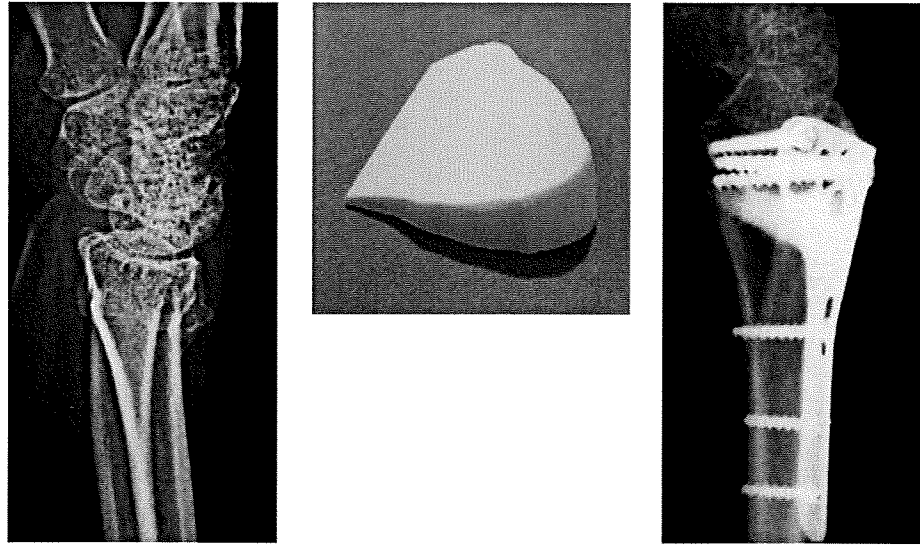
Correction osteotomy for malunited fracture of the distal radius, 48-year-old woman. (a) Preoperative X-ray image of the affected radius, six months after the fracture of the distal radius. (b) Prefabricated IP-CHA. A three-dimensional image was reconstructed with the CT data of the estimated bony defect after correction, and the IP-CHA was fabricated by a three-dimensional milling machine (Roland DG, MDX-20). (c) Post-operative X-ray image, a year after surgery. The malalignment was satisfactorily corrected by the surgery using the prefabricated IP-CHA and a metal plate.
